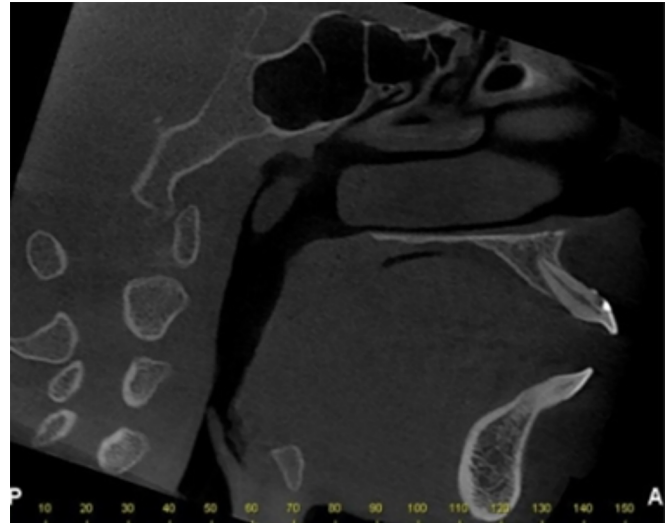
CBCT sagittal reconstruction. Occlusal discrepancy and pronounced open bite.
